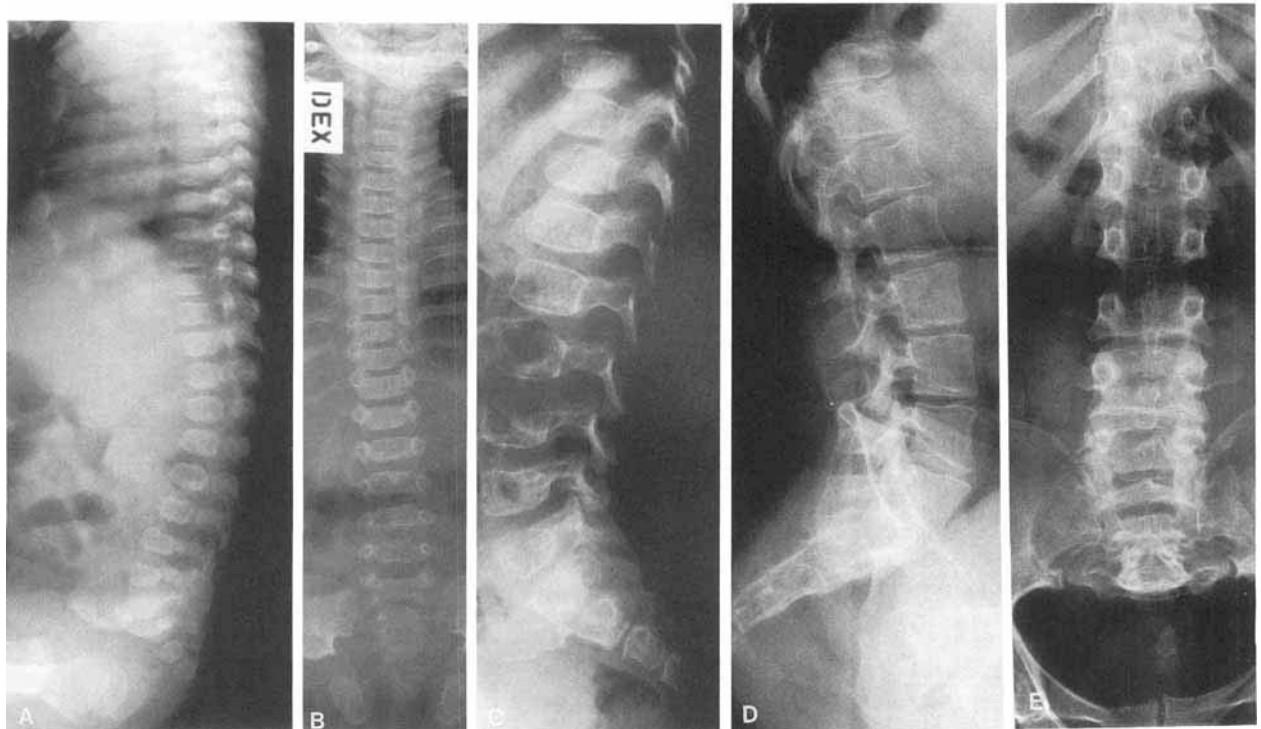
Vertebrae of P2. Radiographs at $\frac{1}{12}$ years (A, B), at $5\frac{1}{12}$ (C), and at 27 years (D, E) show marked platyspondyly and, in the lumbar vertebrae, mild anterior beaking. The costochondral junctions are flared, cupped, and sclerotic. From childhood the platyspondyly is less evident, and at 27 years of age the height of the vertebral bodies is almost normal with only mild platyspondyly at the upper lumbar and lower thoracic spine. The upper anterior corner of the vertebral bodies of T10 and T11 is irregular and dysplastic. The lumbosacral angle is markedly increased, and the intervertebral spaces narrow.
